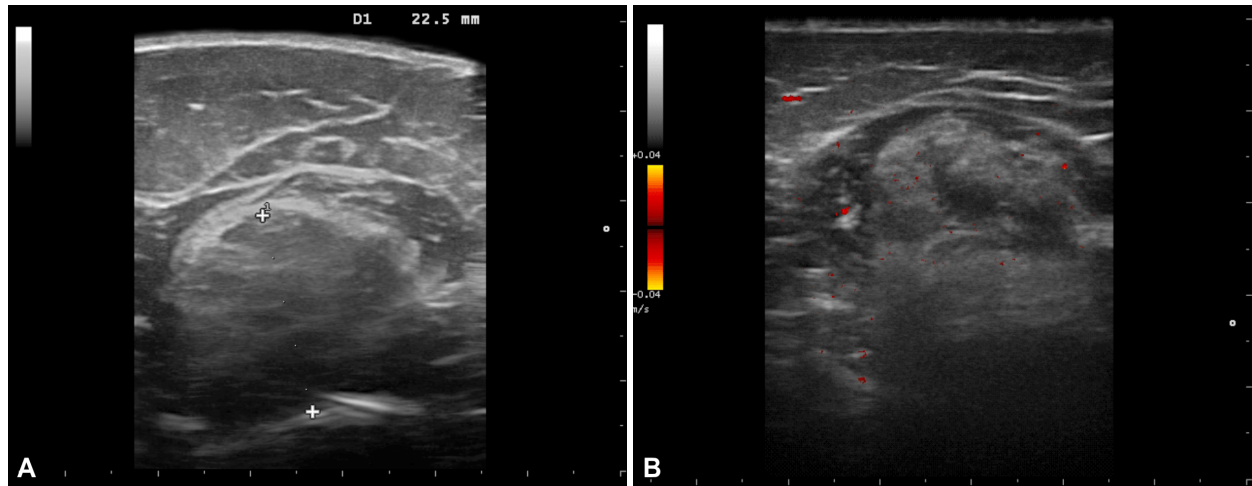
Description. Transverse (A and B) sections, at the level of triceps muscle in the mid-third of the arm: (A) Grayscale image showing unhomogenous area (22.5 mm), deep to the subcutaneous tissue, well-defined, hyperechoic compared to muscle; (B) Power Doppler (PD) ultrasound negative mass, in the same area.
